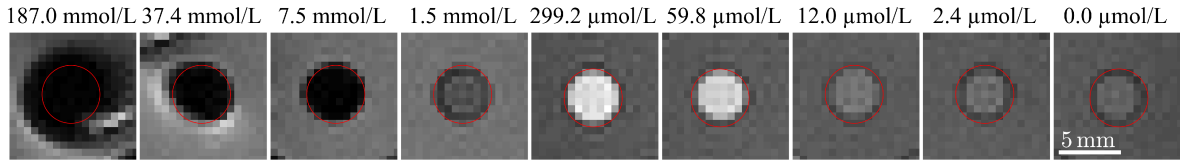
MRI amplitude images of MNP samples with varying c_{Fe} diluted with pure water. The samples were sealed and positioned inside a water bath to obtain sufficient signals. The red circles display the nominal sample positions. Samples containing $> 37.4 \text{ mmol/L}$ induced imaging artifacts, complicating the sample localization. Below $c_{\text{Fe}} > 12 \mu\text{mol/L}$, no significant signal differences are observed between the MNP samples and the surrounding pure water.
